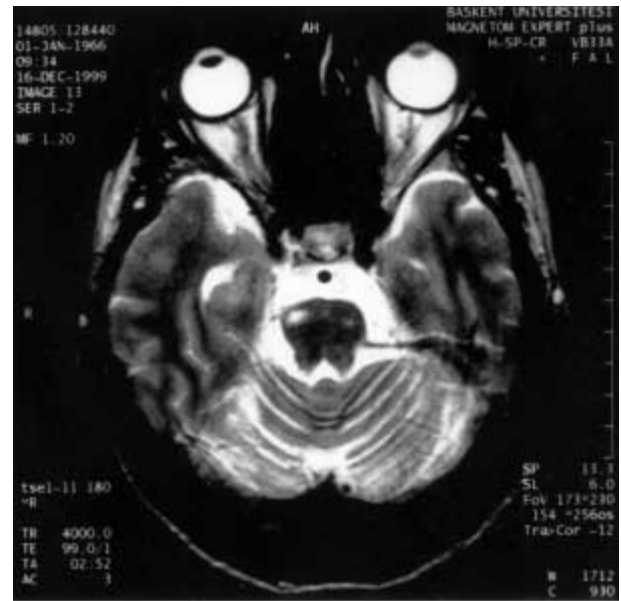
Axial and coronal T2-weighted images show a symmetrical area of hyperintensity in the basis pontis, and a less prominent hyperintense lesion in the right upper pons.
